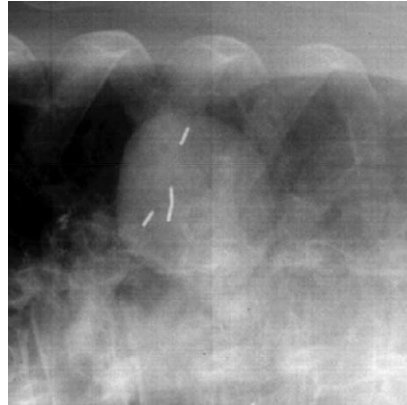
A radiographic projection of a lung tumour with four implanted gold fiducial markers, obtained with a flat-panel amorphous silicon detector [Murphy 2004].
